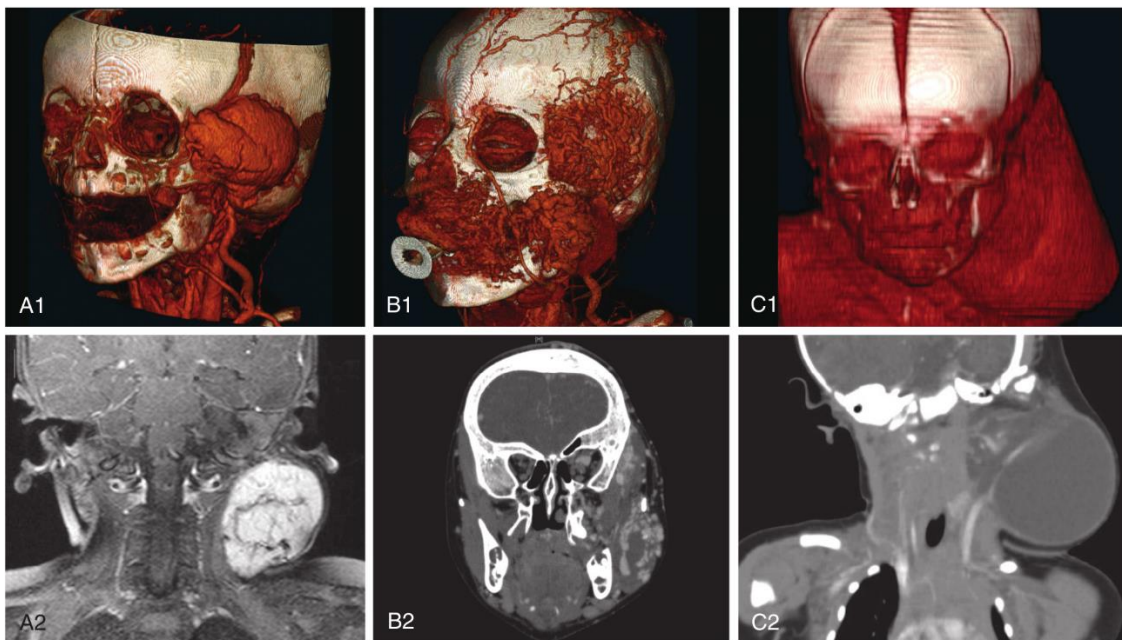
Computed tomographic (top row) and coronal computed tomography (bottom row) vascular anomaly imaging. A, Deep hemangioma of infancy. B, Venous malformation. C, Lymphatic malformation.
